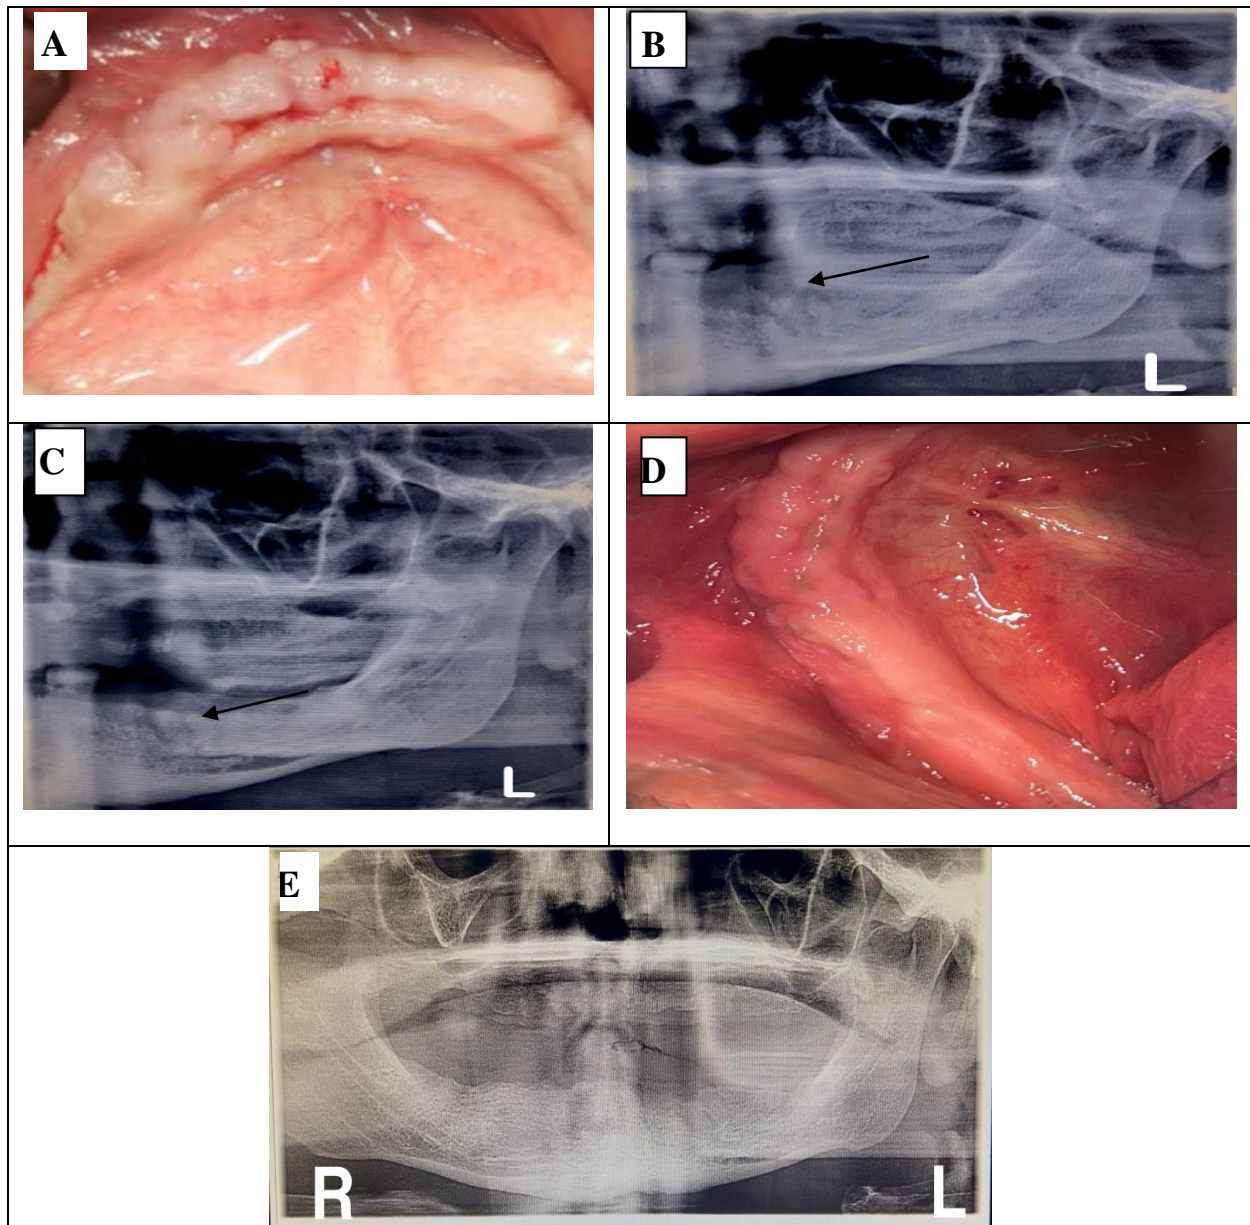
follow up visits: (A) the first follow-up visit and removing the stitches. (B) OPG radiographic picture after one month show a good healing of the lesion (the arrow define the site). (C) OPG radiographic picture after three month show more healing and good amount of bone formation (the arrow define the site). (D and E) the radiographic picture and the clinical picture show complete healing of the operation site after eight
